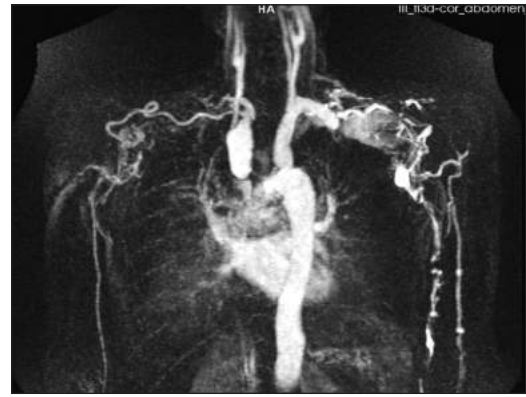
Magnetic resonance imaging: Aneurysm of right innominate artery and occlusion of left subclavian artery.
